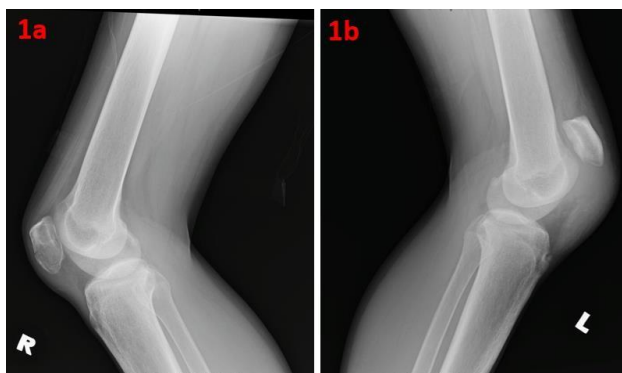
Preoperative right knee radiograph (1a) and left knee radiograph (1b)
